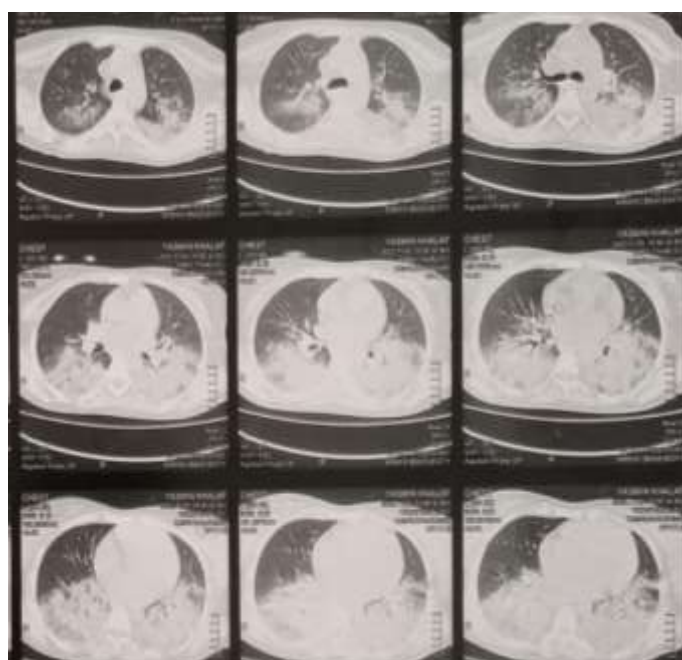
CT chest of the same patient show bilateral lower lobes alveolar consolidation
